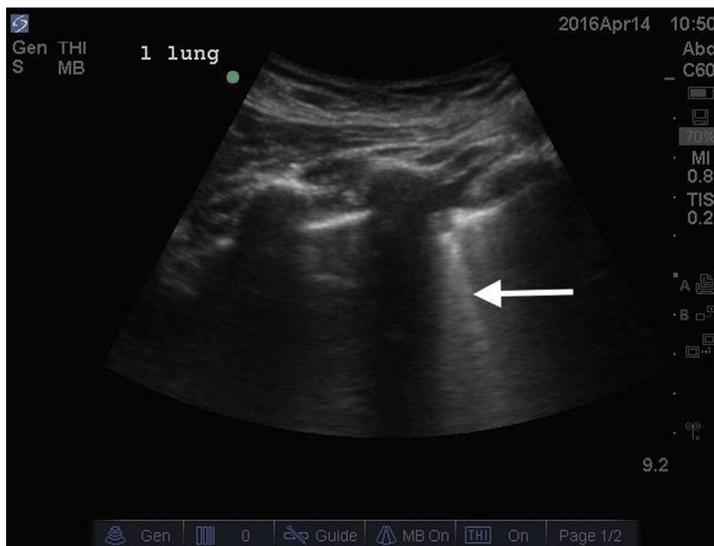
Thoracic ultrasound imaging showing normal lung without evidence of pneumothorax. Comet tail artifacts, or B-lines (arrow), are created between the water and air interface of the visceral pleura in the absence of pneumothorax. (Courtesy of Jeremy Boyd, MD, RDMS, FACEP; Nashville, TN.)
